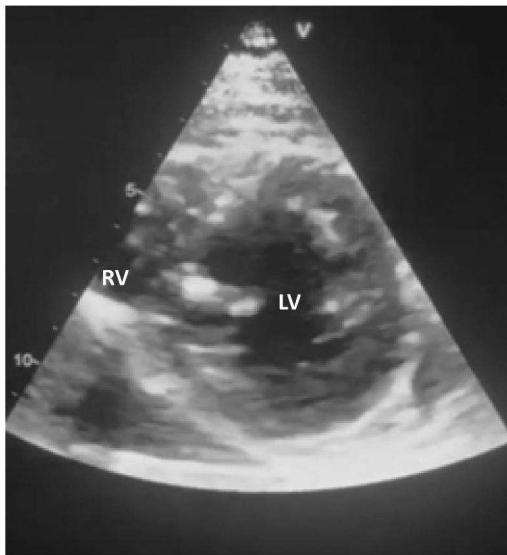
Parasternal short view, showing axial cuts of the LV and RV
